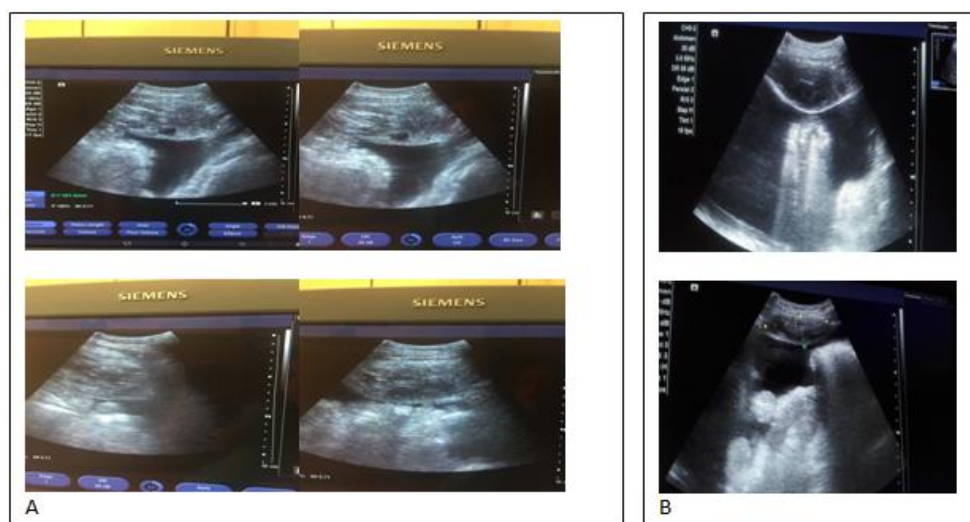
Ultrasound images of the post-puncture intramural hematoma; A: The ultrasound examination at presentation revealed a clearly visible 10 cm large nonhomogeneous oval formation within the abdominal wall highly suggestive of intramural hematoma. B: six weeks later we registered a significant reduction of the hematoma size
